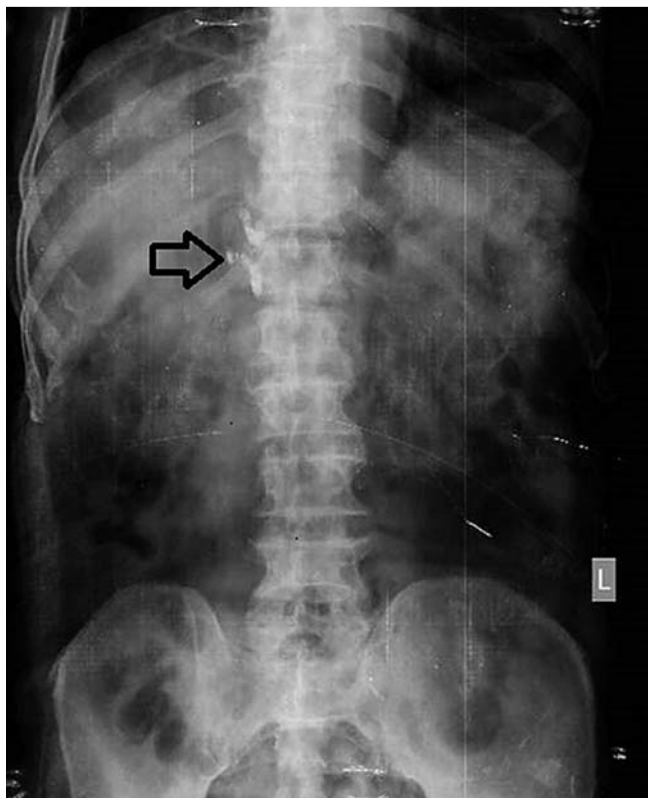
Abdominal radiograph during the present admission, showing two coils, one of which was deformed (black arrow).
